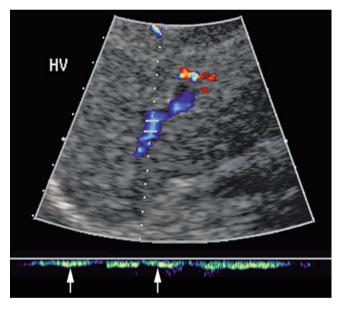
Budd-Chiari syndrome. Color and spectral Doppler of liver and hepatic vein showing small intrahepatic vein with minimal blood flow (*arrows*) due to occlusion of the veins distally
